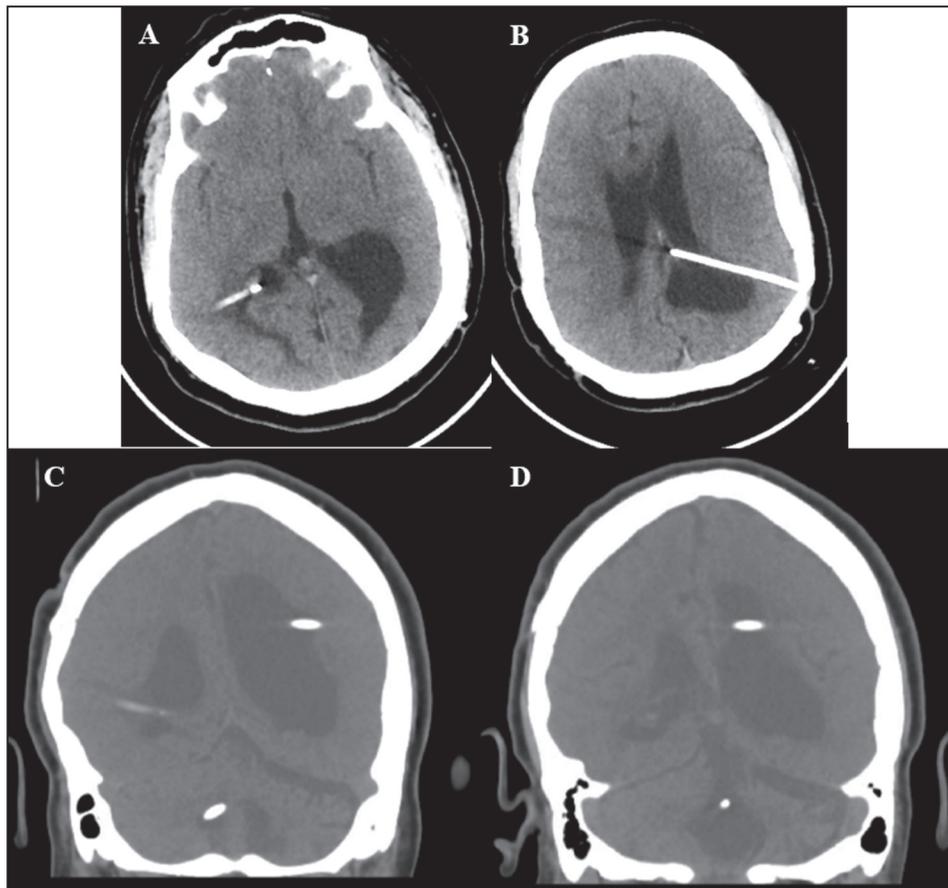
(A, B) Axial (brain window) and (C, D) coronal (bone window) post-operative head computed tomography images displaying the course of ventriculoperitoneal shunt as well as the resolution of previous ventriculomegaly following repair of strangulated ventral hernia and peritoneal catheter re-positioning
